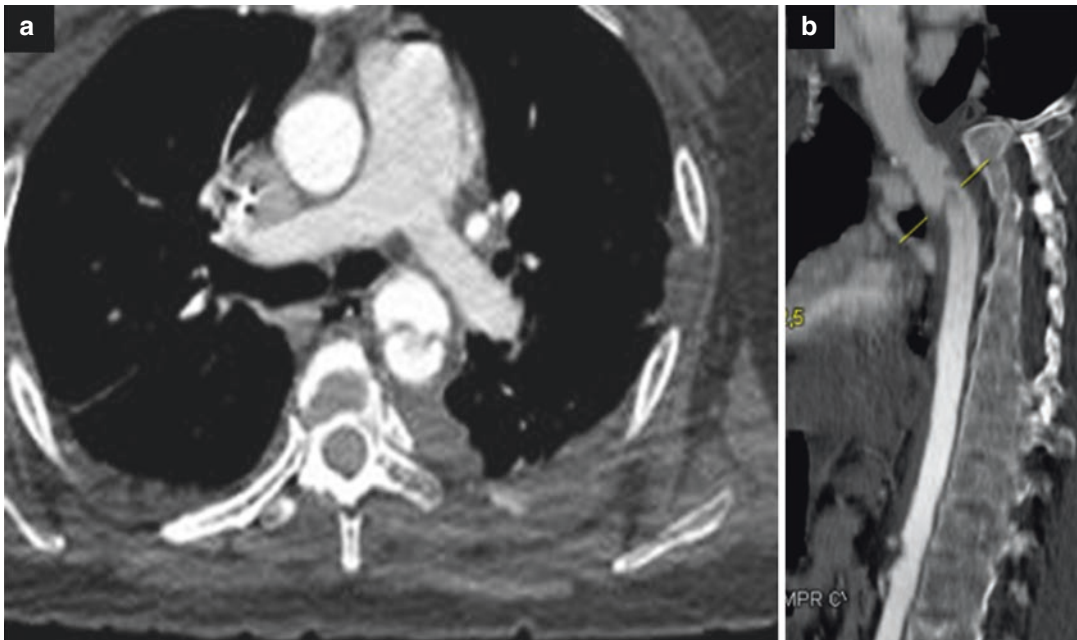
Traumatic pseudoaneurysm with pseudocoarctation (obstructive flap reducing the caliber of the descending aorta). (a) Axial CT scan; (b) reformat linear image
